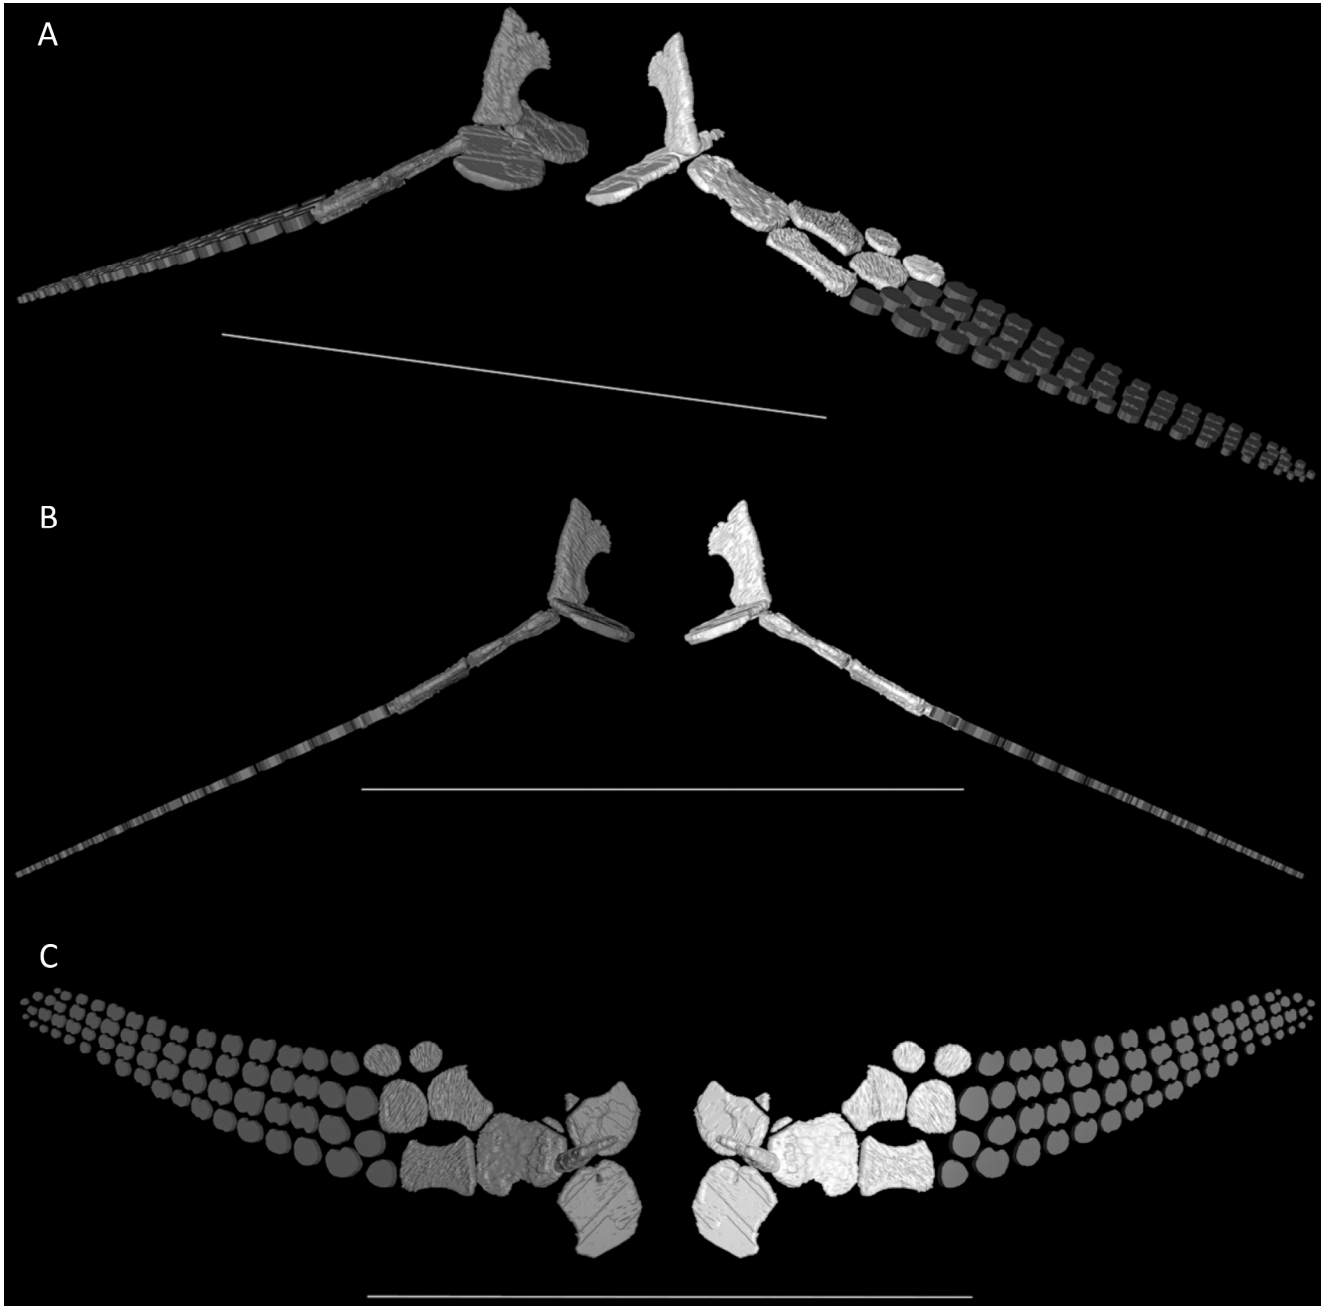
3D reconstruction of the pelvic girdle and hindfins of *Besanosaurus leptorhynchus* based on the CT scans of BES SC 999 in laterofrontal (A), dorsal (B), and frontal (C) view. Shang and li (2013: fig. 1) and McGowan & Motani (2003: fig. 70) used as references to reconstruct the hindfins. Original elements in white; element deduced from the available material in grey. Scale bars represent 50 cm.
